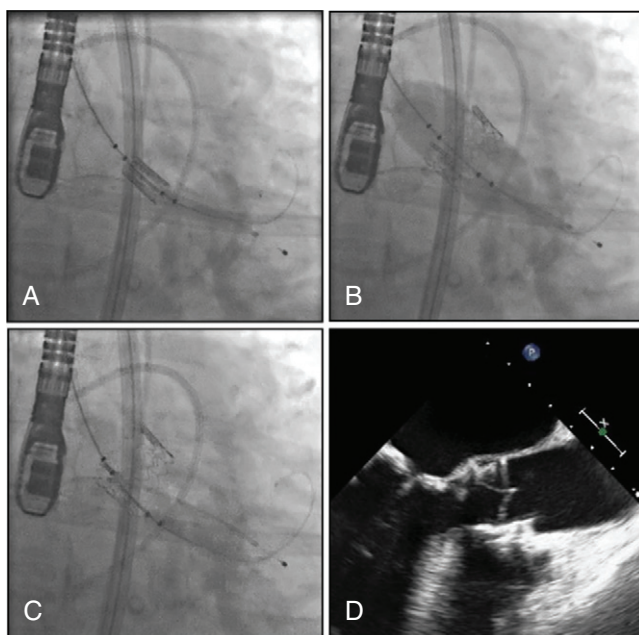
SAPIEN valve implantation. A, The SAPIEN valve is positioned across the native aortic valve. B, With rapid ventricular pacing, the delivery balloon is inflated to deploy the valve. C, The delivery balloon is deflated, revealing a fully expanded stent valve. D, Transesophageal echocardiogram after deployment shows two of the pericardial leaflets coapting during diastole.
